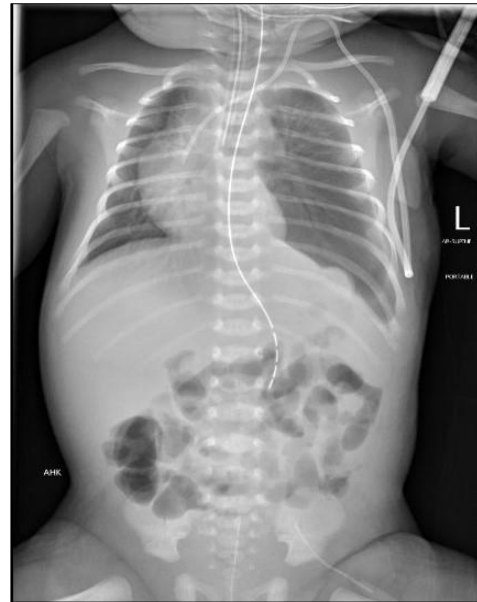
Chest x-ray 5 days after surgery.
